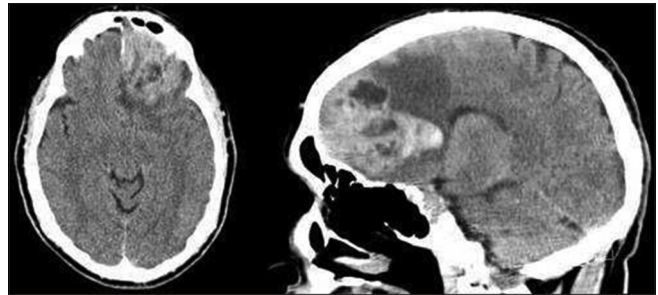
CT head without contrast demonstrates a hyperdense left frontal mass with the erosion of the inner table of the frontal sinus, near midline.
